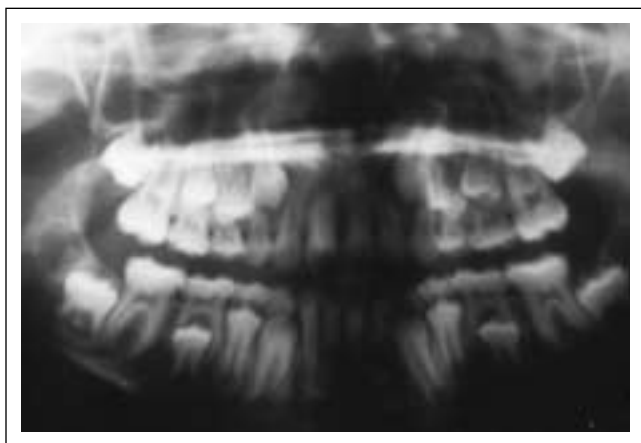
The panoramic radiograph and the postero-anterior projection show a fracture of the left condyle (arrow).
